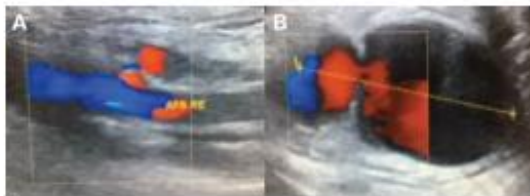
[A, B] Preoperative two-dimensional color Doppler ultrasound to assess femoral artery access.
